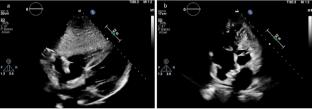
Post-procedure echocardiography. The subcostal (a) and the four-chamber projection (b) showed a persistent small spur of thrombotic material on the posterior wall of the right atrium measuring up to 15x5 mm.
